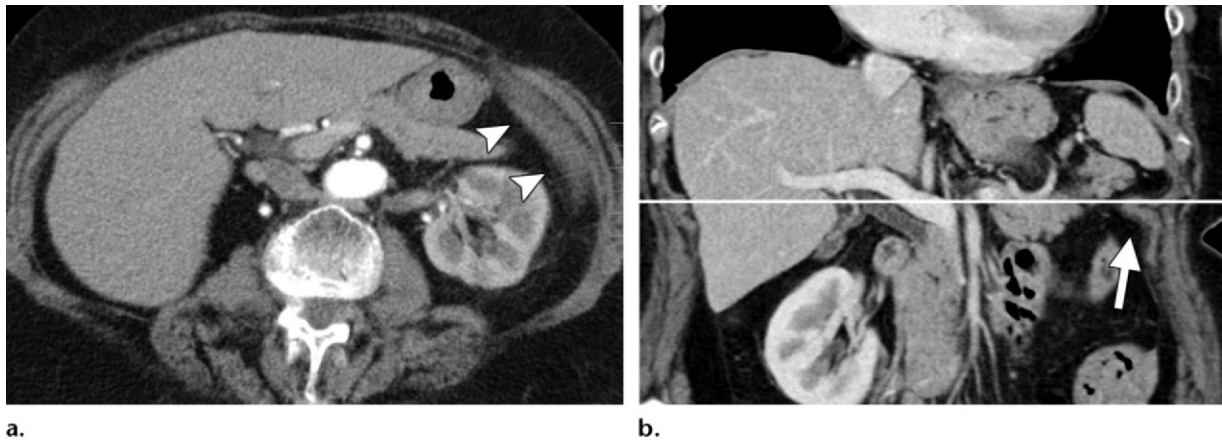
Diaphragmatic slip in a nontrauma patient. (a) Axial CT image shows apparent thickening of the left hemidiaphragm (arrowheads), a finding suggestive of an in-plane diaphragmatic slip or redundancy of diaphragmatic muscle. (b) Coronal reformatted CT image clearly depicts a fold in the intact diaphragm (arrow) at the level at which a was obtained (horizontal white line).
